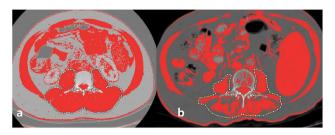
Sarcopenia assessment the areas of total paravertebral muscle at the mid-level of the third lumbar vertebrate by CT scan. (A) Example of a non-sarcopenic man with normal muscle mass, (B) Example of a sarcopenic man with reduced muscle mass *CT: Computed tomography*
